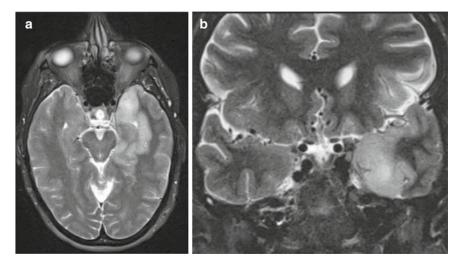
(a) Axial and (b) coronal T2-weighted MRI demonstrating a lesion of increased signal intensity in the left anteromedial temporal lobe in HSV-1 encephalitis. Courtesy of Darren O'Neill M.D
